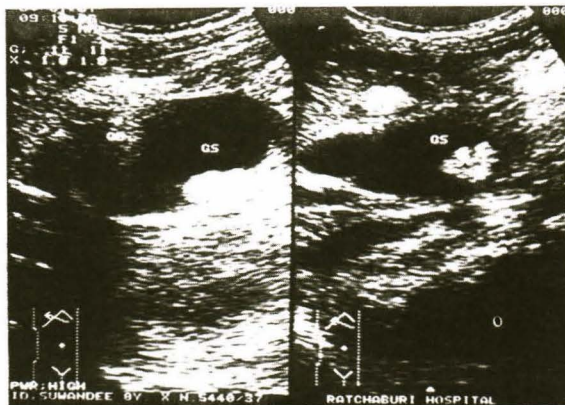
Abdominal ultrasonography showing multiple gall stones.
